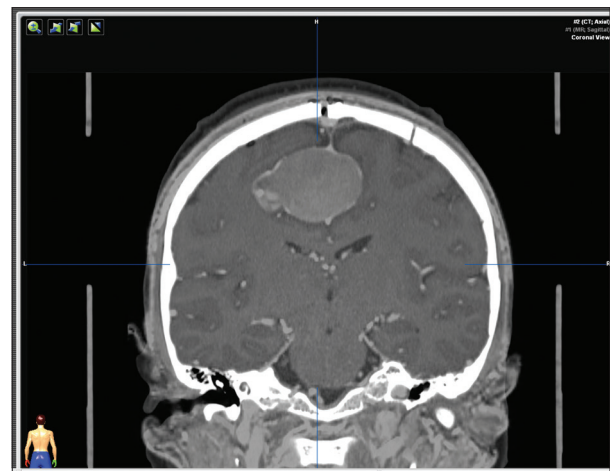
Fusion with postoperative computed tomography scan and preoperative magnetic resonance imaging
